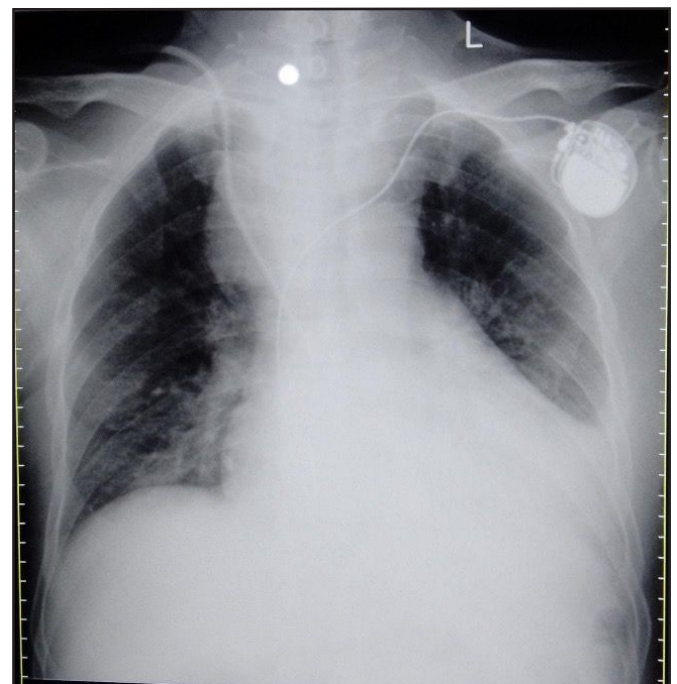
Chest X-Ray post PPM implantation
